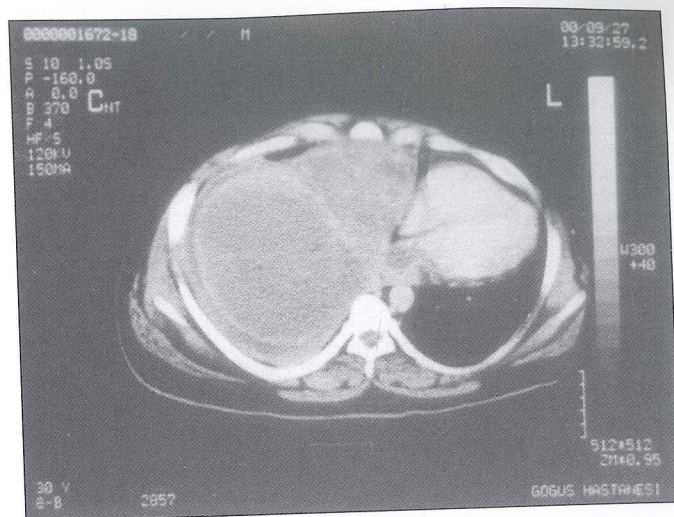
Computed tomography of the thorax
